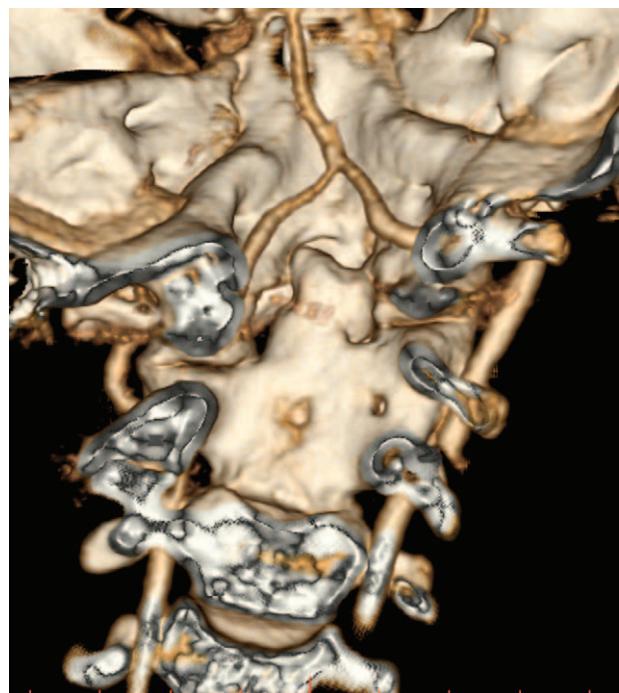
Three-dimensional reconstruction of the angio computed tomographic scan. Direction of view is from occipital to rostral. Note the distance between the tip of the odontoid process and the course of the vessel (arteria basilaris).
